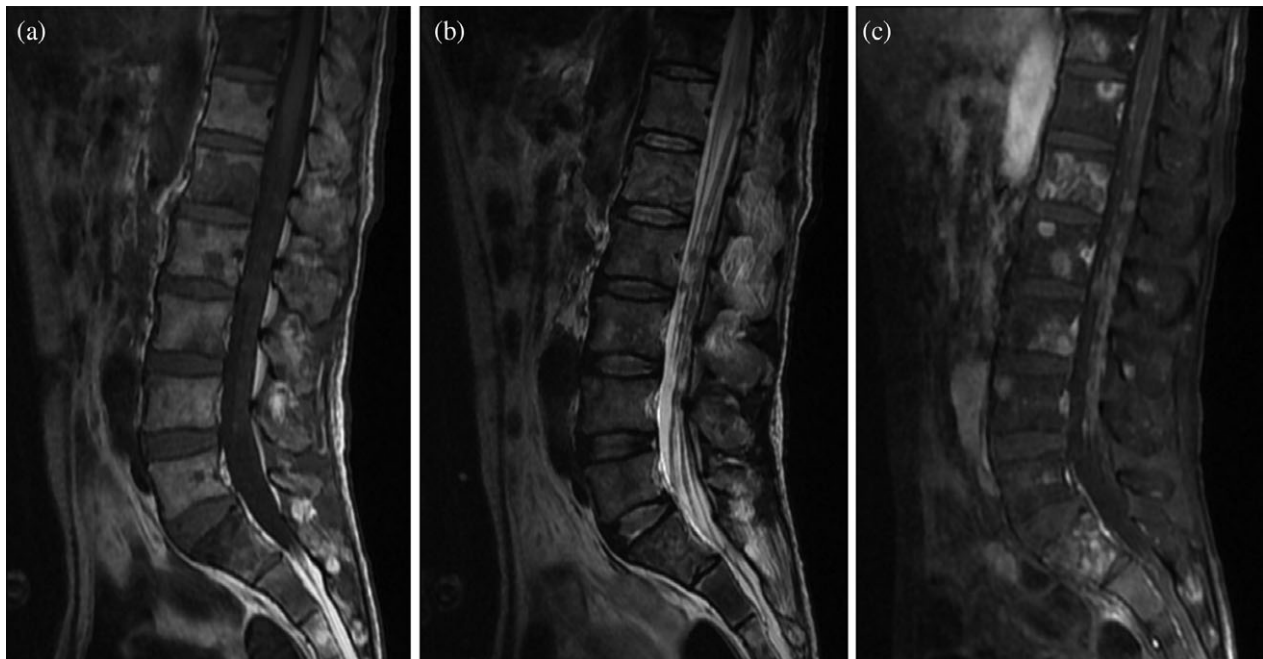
Sagittal sections of magnetic resonance imaging (MRI) of the lumbar spinal cord. T1-weighted imaging showed (a) multiple hyperintense and T2-weighted imaging showed (b) multiple hypointense intradural extramedullary nodules. (c) Contrast-enhanced MRI of the lumbar spine showed multiple intradural extramedullary nodules with abnormal enhancement.
